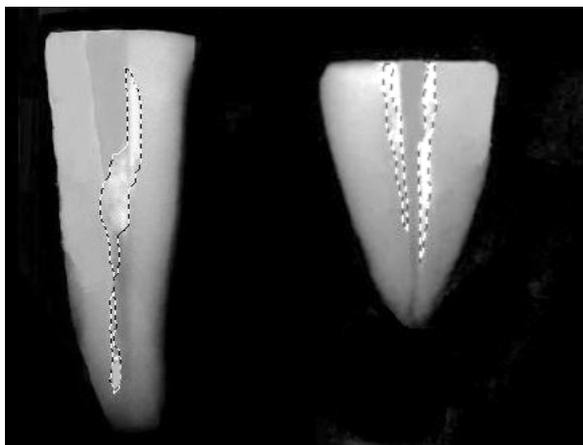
Radiograph to Trace Remaining Filling Material in Both Bucco-Lingual and Mesio-Distal Directions by the Use of magnetic Lasso Tool.
